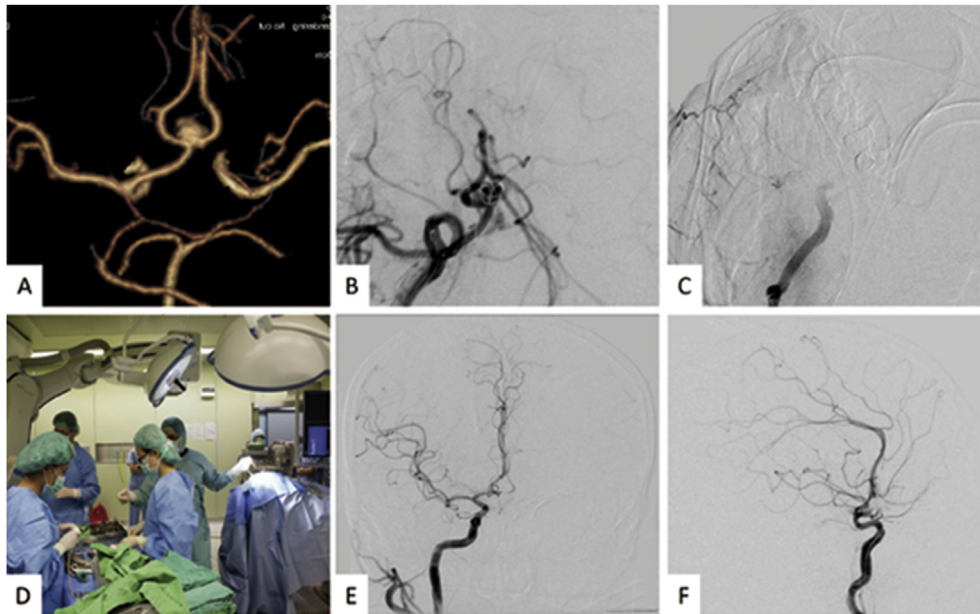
CTA showed a large aneurysm at the anterior communicating artery (Fig. 2A). Unexpected rupture during the first coil placement was found (Fig. 2B). Arrested intracranial blood flow secondary to increased intracranial pressure was detected by the angiography (Fig. 2C). Photo showing dual-trained neurovascular surgeons can perform quick conversion from endovascular embolization to salvage EVD placement without moving the patient in the hybrid OR (Fig. 2D). Final angiography showed patent flow in the bilateral anterior cerebral arteries (Fig. 2E,F).
